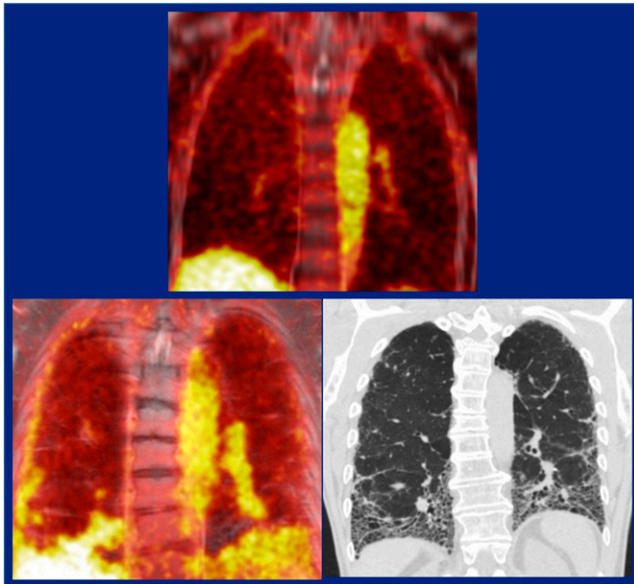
Collagen-targeted ^{68}Ga -CBP8 PET imaging in a healthy individual (top) and in an individual with idiopathic pulmonary fibrosis (bottom left), with corresponding CT scan (bottom right). The tracer binds type I collagen with high affinity and specificity and, in this first-in-human study, was well tolerated and safe with rapid renal clearance.
